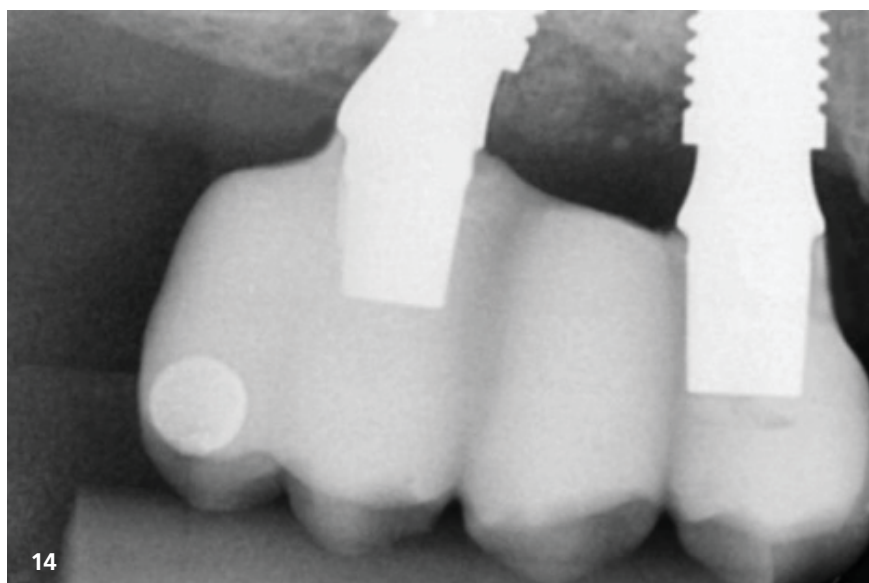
X-ray 24 months later.
